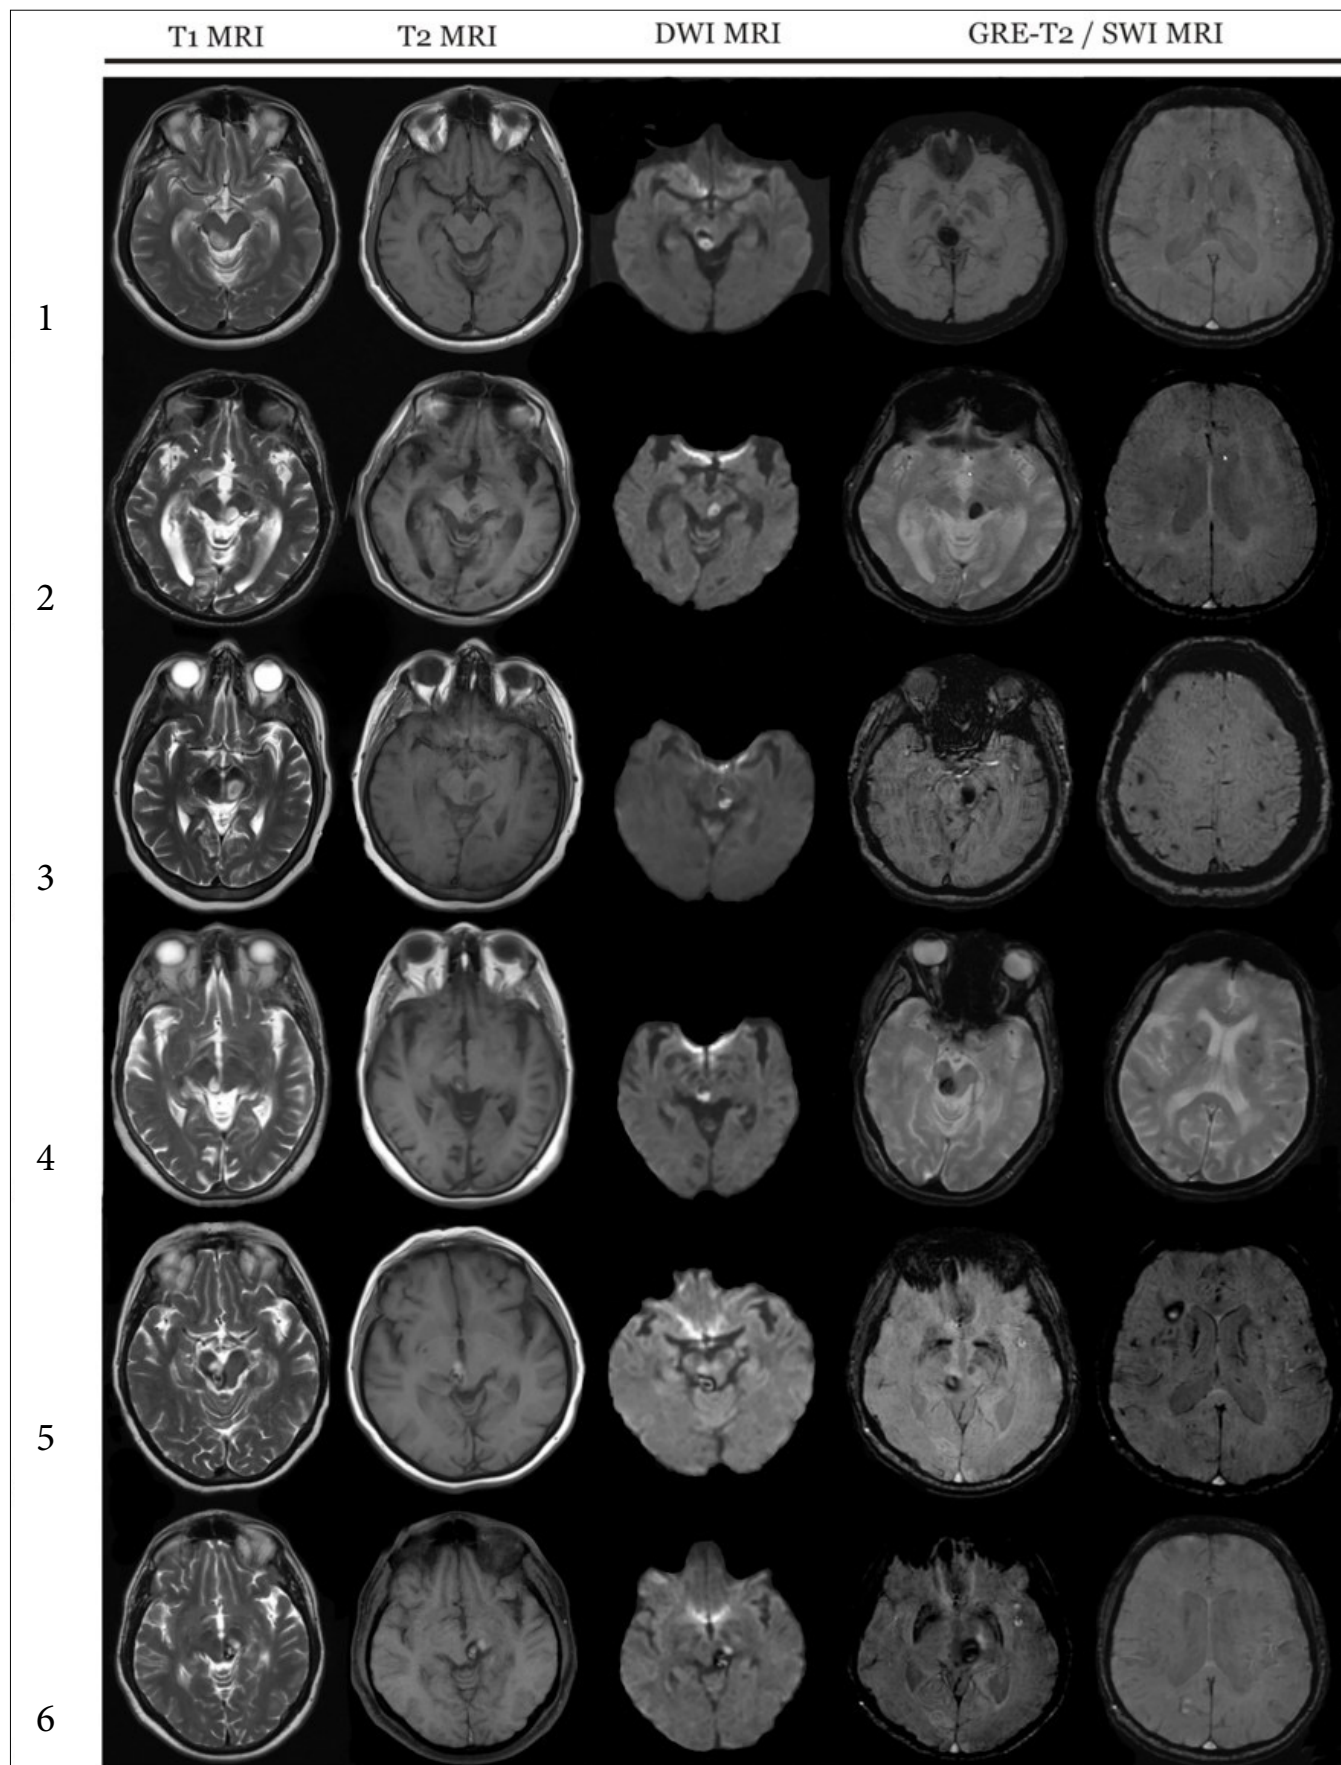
MRI sequences of the present series demonstrate mesencephalic hemorrhage in 6 patients. Susceptibility-weighted imaging (SWI) and T2*-weighted gradient-recalled echo (GRE) identified cerebral microhemorrhages (axial plane) in the parietal lobe and deep white matter in patients P3 and P4. Patients P5 and P6 had a rim of signal loss due to hemosiderin and MRI signal characteristics of a recent hemorrhage in the midbrain suggesting small cavernoma malformation. Patient P5 had small cavernomas with hemorrhagic component in the temporal and parietal subcortical areas which were demonstrated by SWI MRI.
